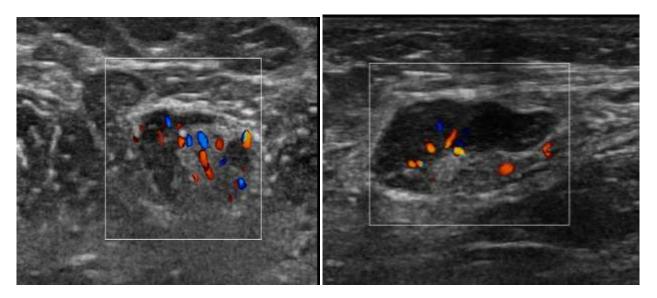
Reactive Lymph Nodes are Shown on Echograms with color Doppler Mapping
